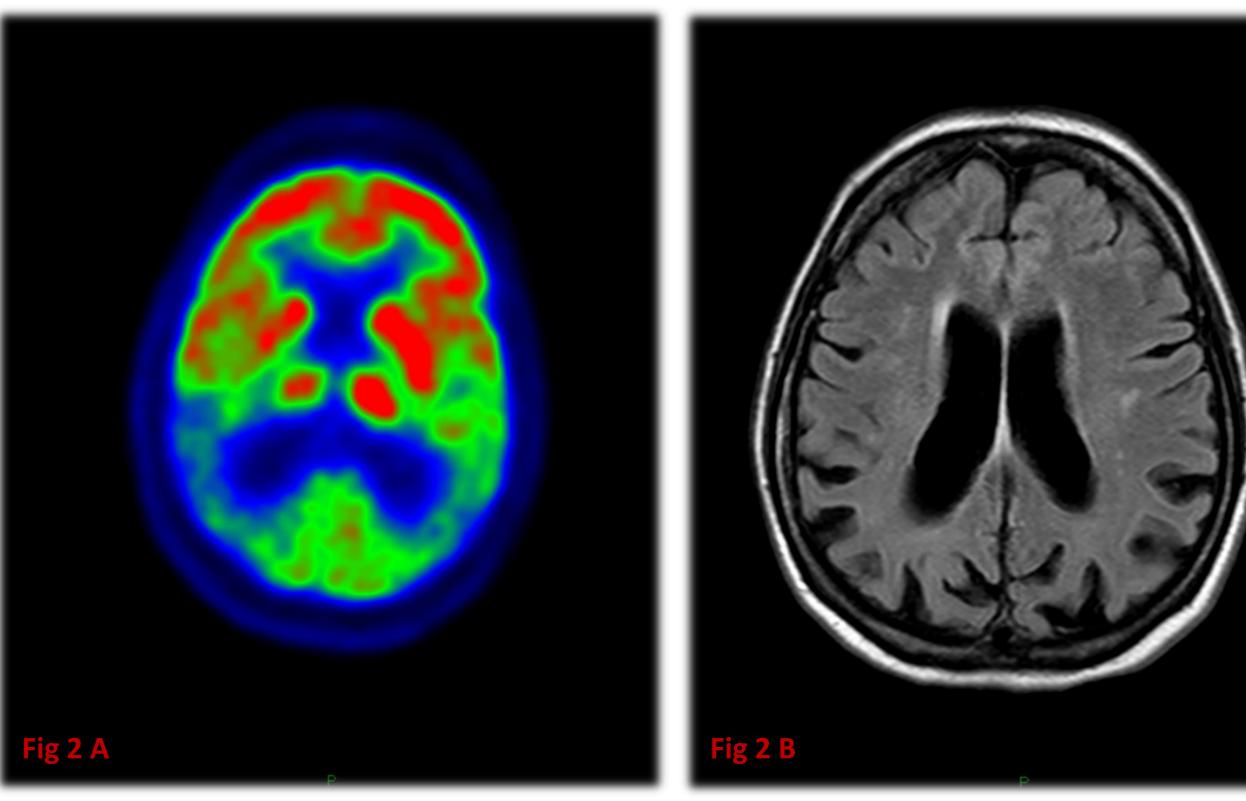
A Brain MRI (FLAIR sequences) showed bilateral posterior cortical atrophy. Fig 2 B Brain FDG-PET confirmed primary posterior hypometabolism.
